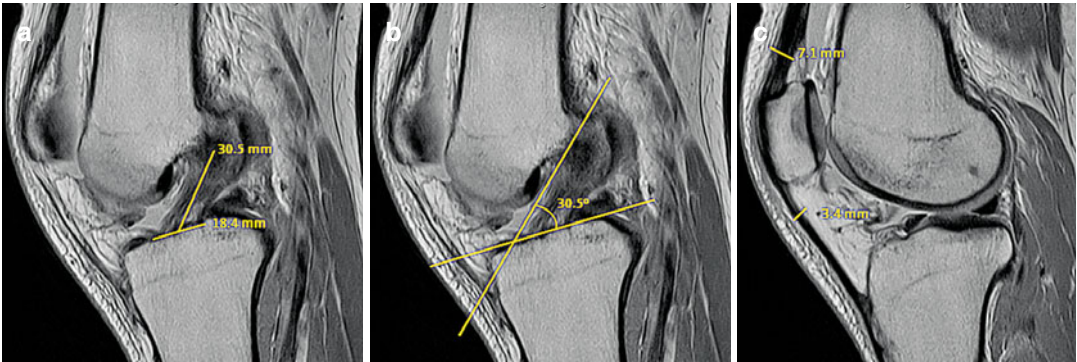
MRI measurements: (a) on tibial insertion site and ACL length, (b) on ACL inclination angle, and (c) on the quadriceps and patellar tendon thickness. The
